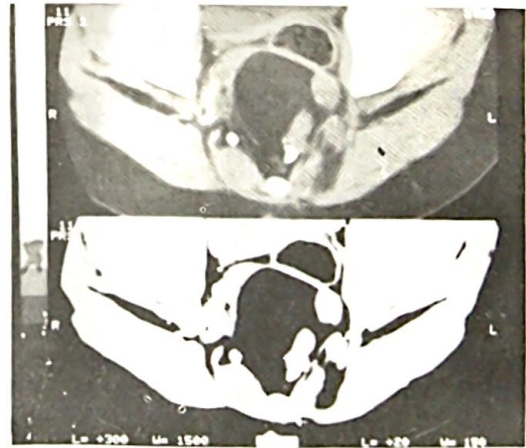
(Case 9): CT scans: (Upper scan at bone windows, and the lower one at soft tissue window) showing a presacral (post-rectal) mass with central fatty tissue and with soft tissues and calcific nodules on its lateral walls.
